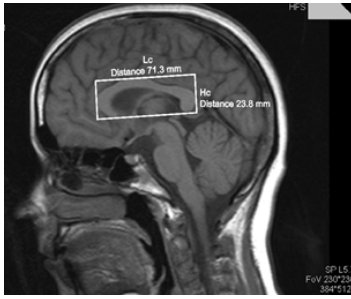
MEASUREMENT CALLOSUM (MIDSAGITTAL MRI)
